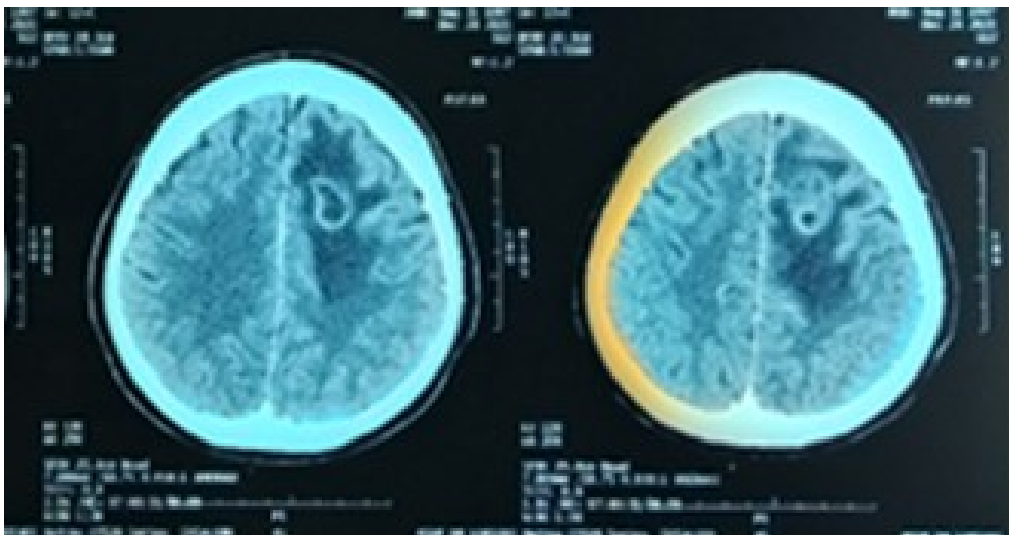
Head CT scan showed multiple cystic ring lesion at frontotemporal
